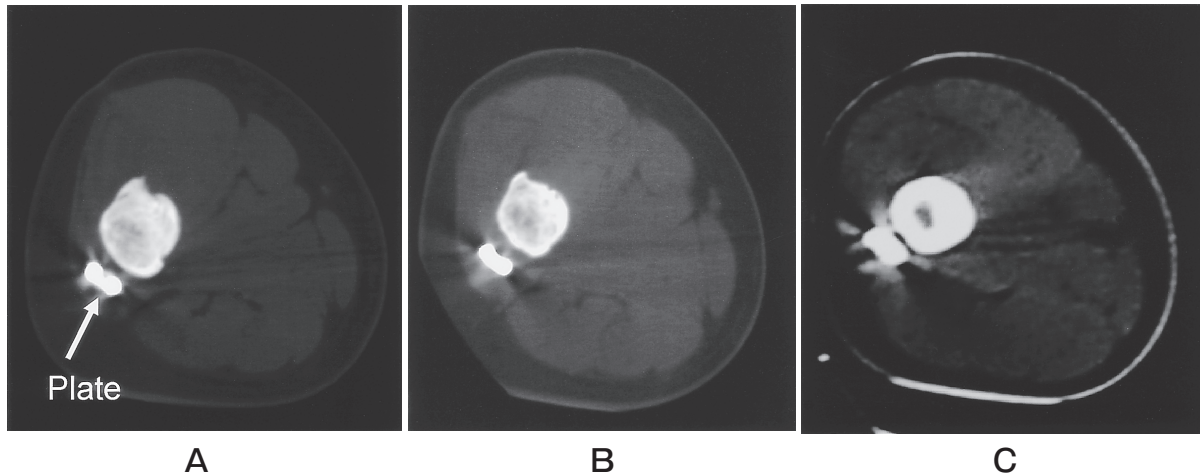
The change of the femur on the computed tomograms after plating in Case No. 1. A, 3 months; B, 7 months; C, 18 months after plating.
